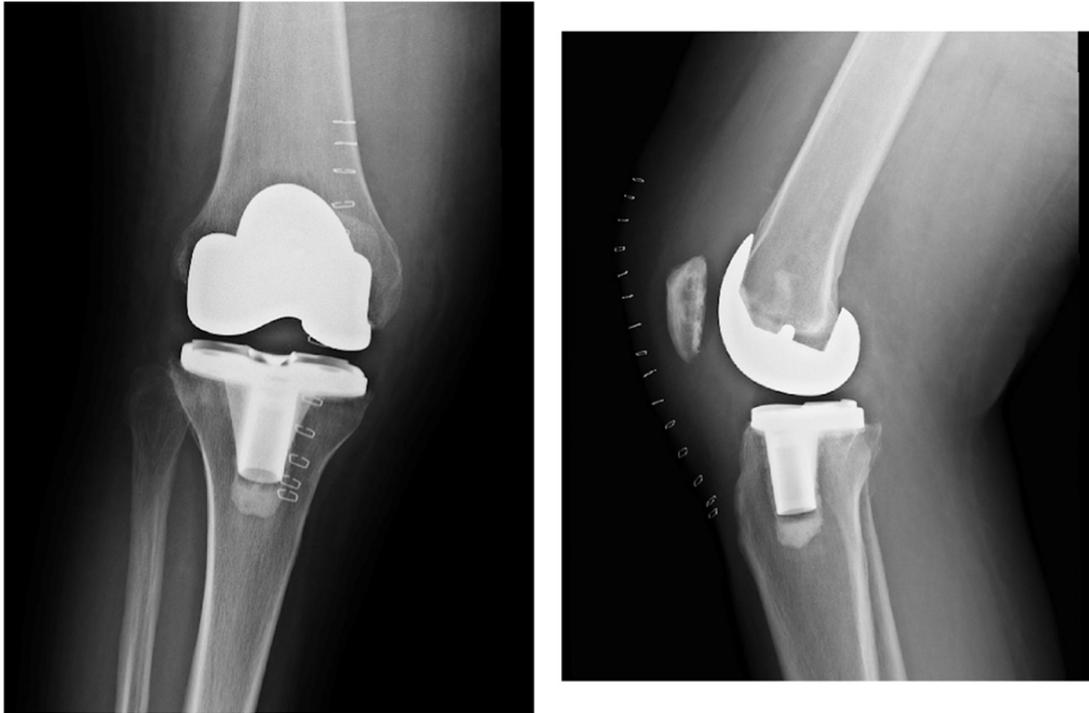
X-rays immediately after primary TKA.
